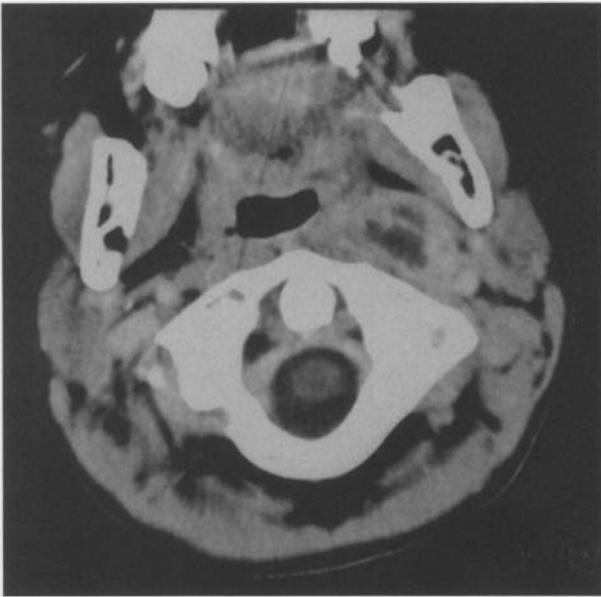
CT scan of the upper neck showing a retropharyngeal abscess on the left side
